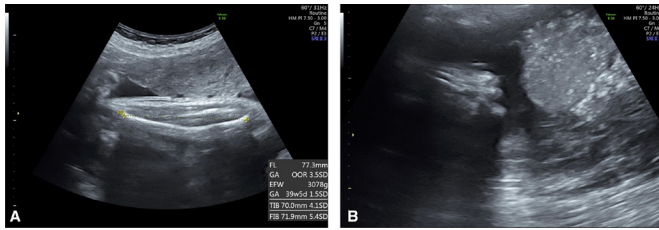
Fetal ultrasound at 36 weeks of gestation. (A) The length of right tibia is 70.0 mm (+4.1 SD). (B) The left fingers are folded.
